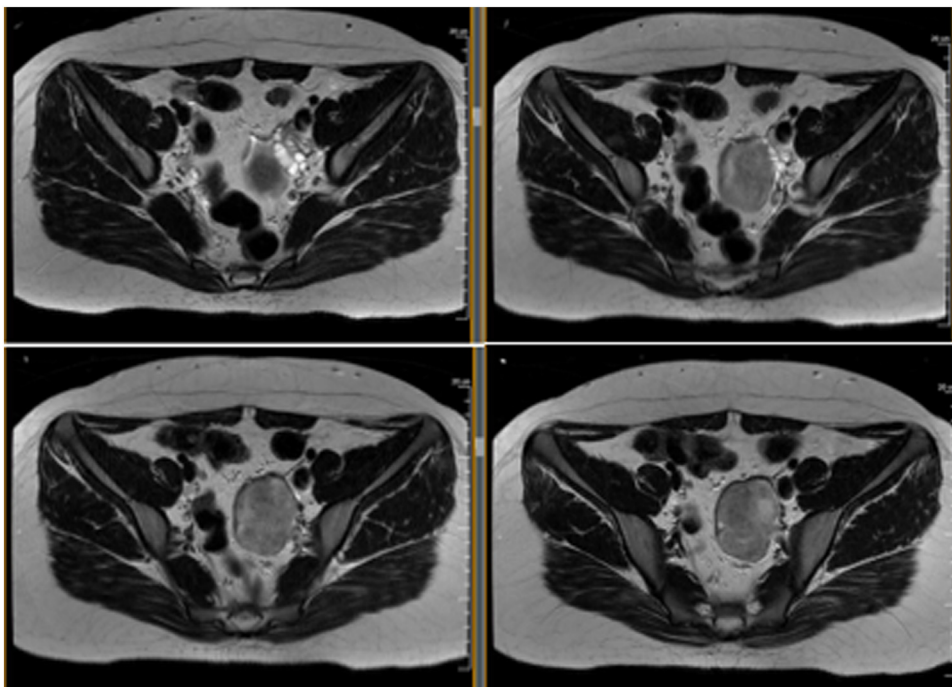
Clockwise from top left – cranial to caudal axial MRI imaging highlighting an 8-centimeter pelvic mass.
